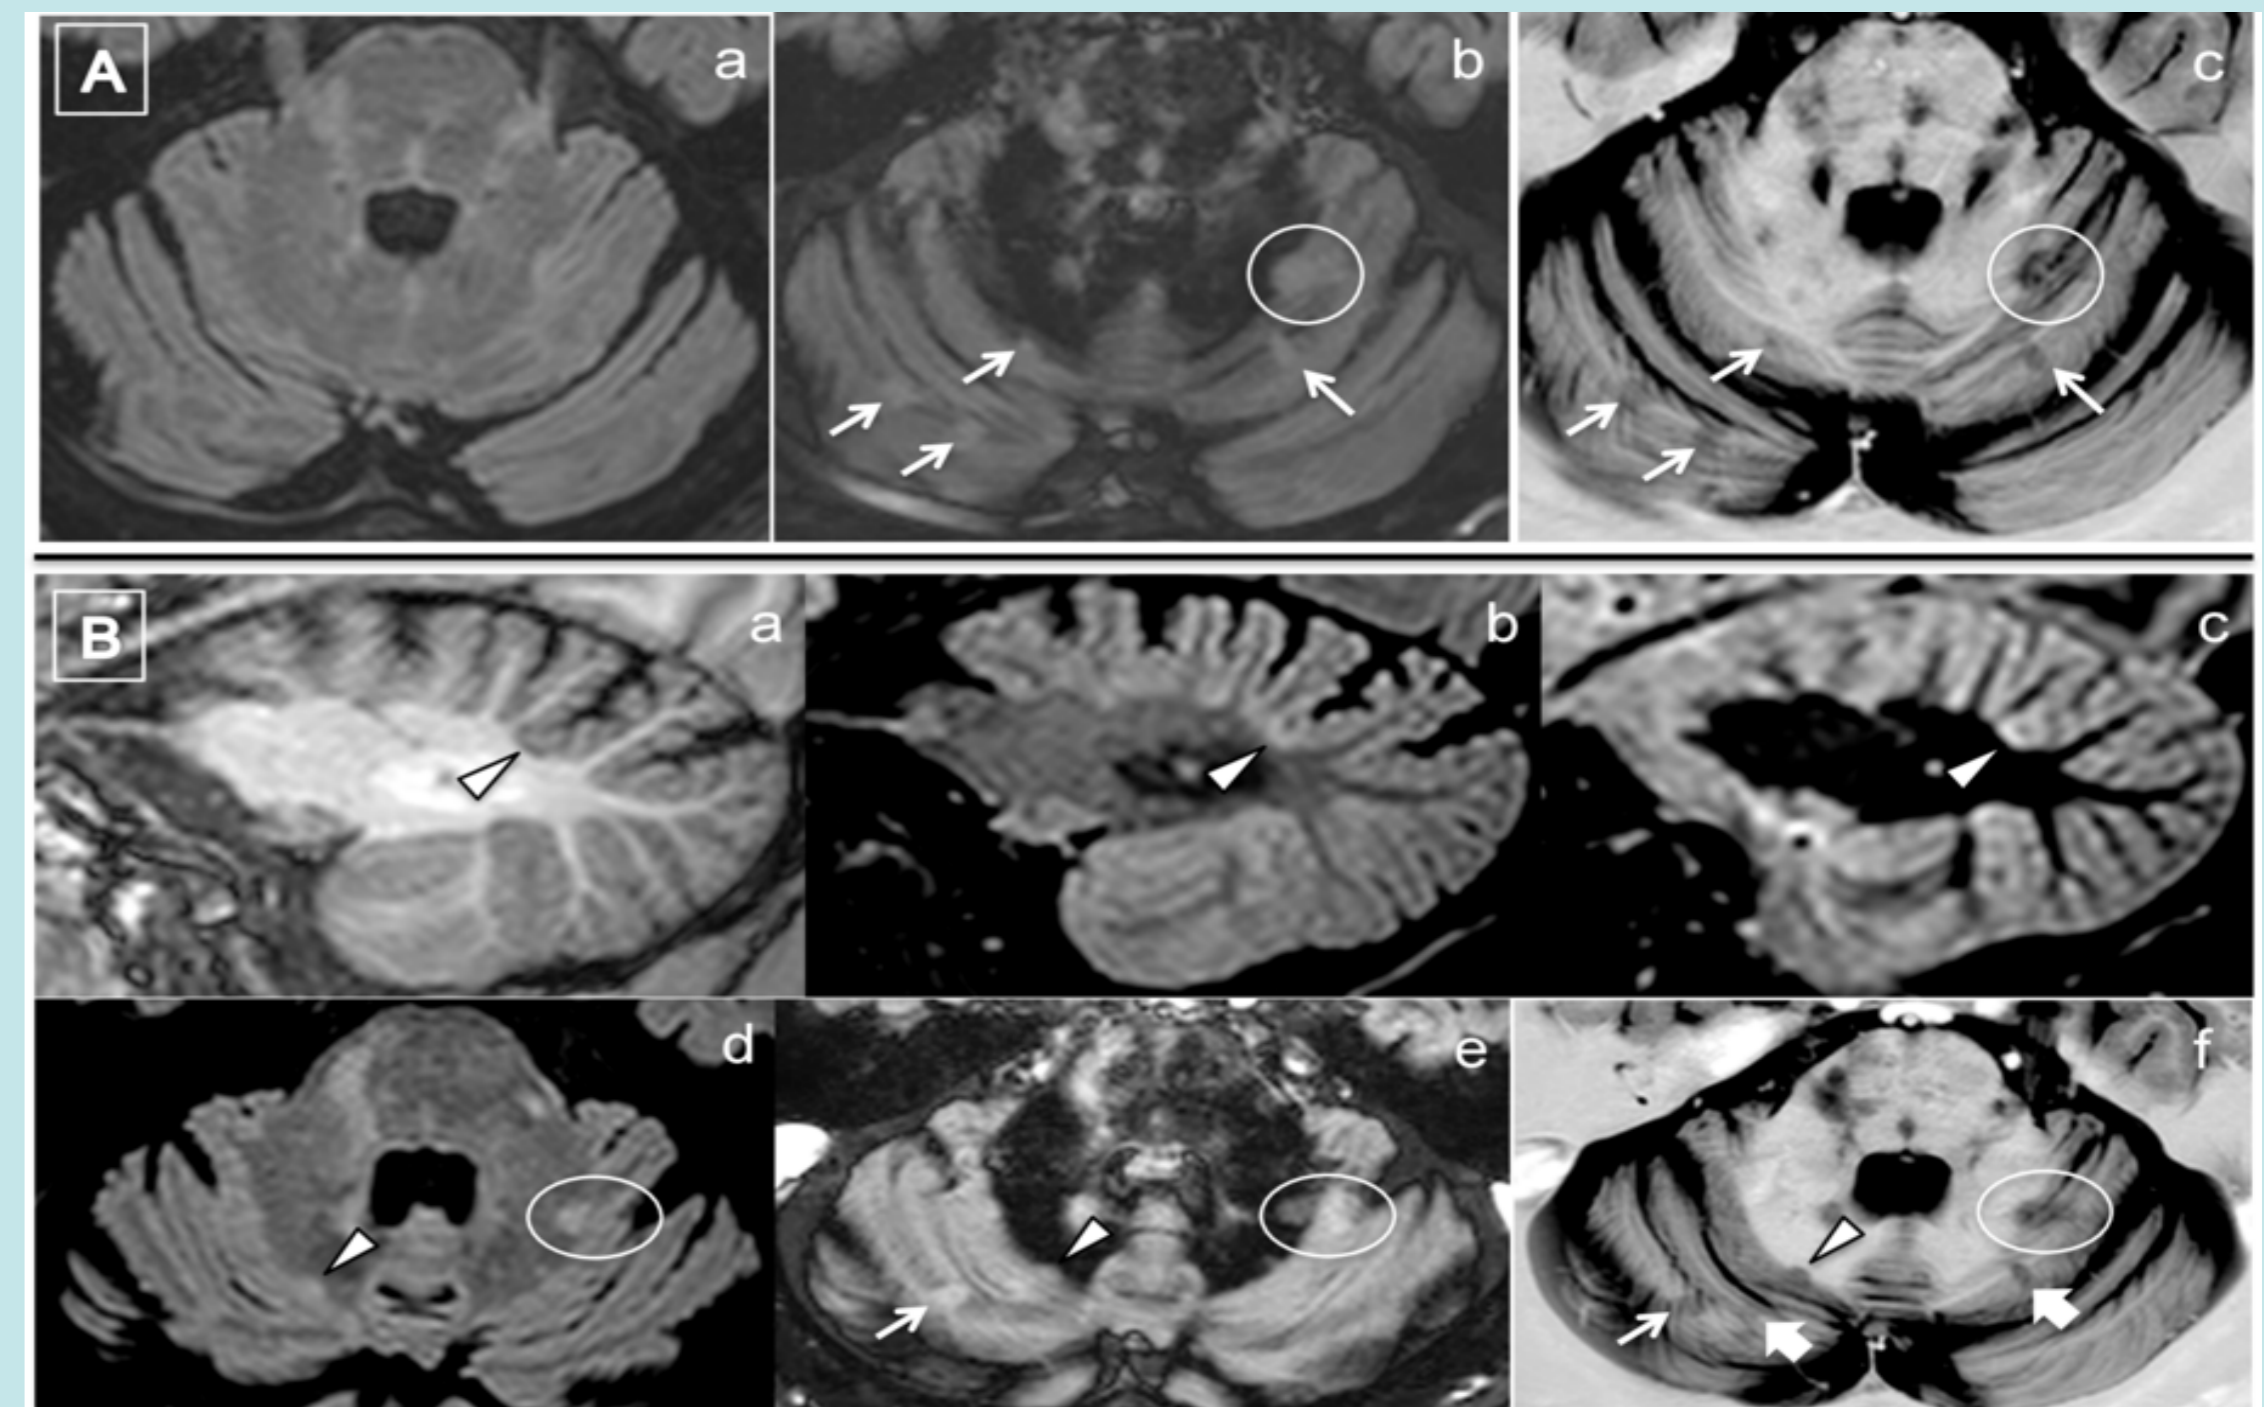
A. Patient with RRMS. No GM lesion can be identified on the FLAIR (a) image, while at least 5 CL (mixed) can be recognized both on DIR (b) and PSIR (c) images (arrows and circle). Both sequences are needed to clearly identify and delimitate the lesion in the circle that encompasses multiple folia. B. Patient with RRMS. Sagittal T1 (a), FLAIR (b) and DIR (c) images and axial FLAIR (d), DIR (e) and PSIR (f) images of a mixed white/grey matter lesion (arrow-head). This lesion seems confined in the subcortical white matter on FLAIR images, but is definitely classified as mixed on PSIR images. A CL (thin arrow) is clearly visible on both DIR (e) and PSIR (f) axial images, while two CL detectable by PSIR, but not by DIR, are indicated by the thick arrows. In the circle, a lesion that was considered a subcortical WML on FLAIR, was reclassified as mixed on the base of the combined examination of DIR and PSIR images. PSIR allowed a better morphological characterization of WM lesions compared to FLAIR.
